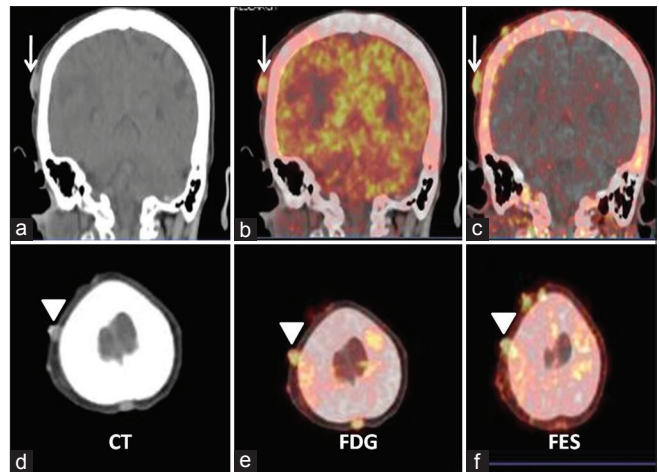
Coronal and axial computed tomography (a and d), fused ¹⁸F-fluorodeoxyglucose (b and e), and fused ¹⁸F-fluoroestradiol (c and f) positron emission tomography-computed tomography images. Images show multiple scalp nodules with good ¹⁸F-fluorodeoxyglucose and ¹⁸F-fluoroestradiol uptake. Findings suggest estrogen receptor expressing scalp metastases
